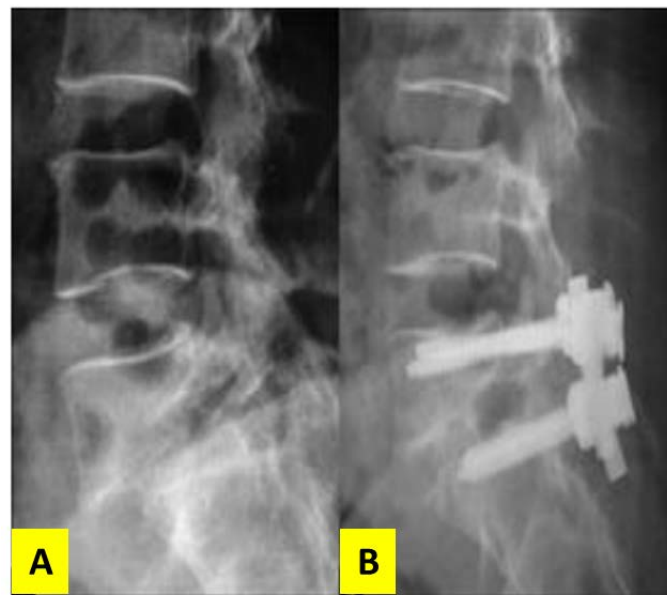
Patients with spondylolisthesis of L5-S1 (A) Pre-op X-ray. (B) Post-op X-ray.
